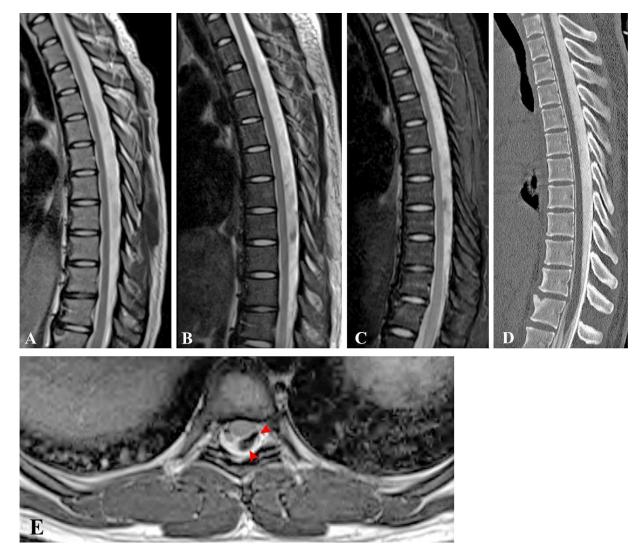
Evidence of CSF flow abnormalities are demonstrated on sagittal T2-weighted MRI reformats of the thoracic spine at the following time-points: (A) initial injury, (B) 3-month postinjury, and (C) 4-month postinjury. (D) CT myelogram of the thoracic spine demonstrates serpiginous CSF filling defects. (E) Axial T2-weighted MRI of the thoracic spine showing CSF flow abnormalities (red arrows). CSF, cerebrospinal fluid; CT, computed tomography, MRI, magnetic resonance imaging.
